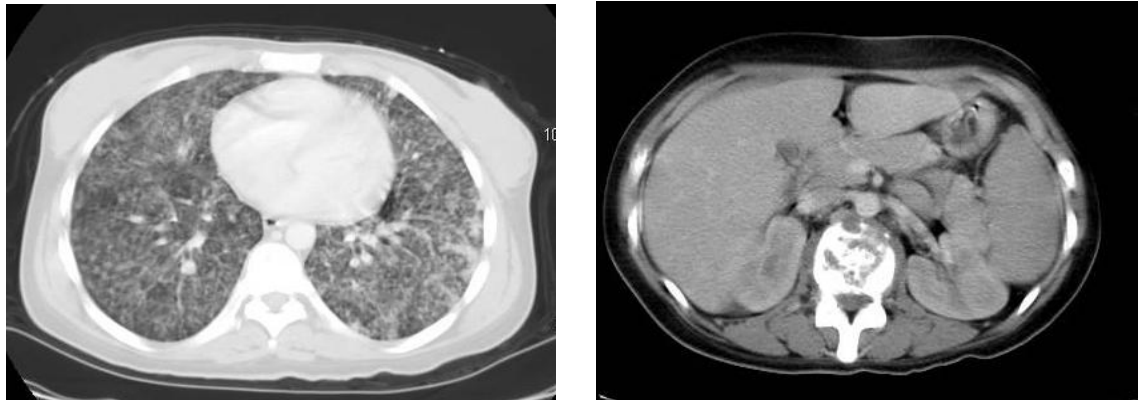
(a & b): HRCT lower cuts of relapsed patient show extensive miliary nodular and fine reticular infiltrates as well as spondylodiscitis at dorso-lumbar region.
